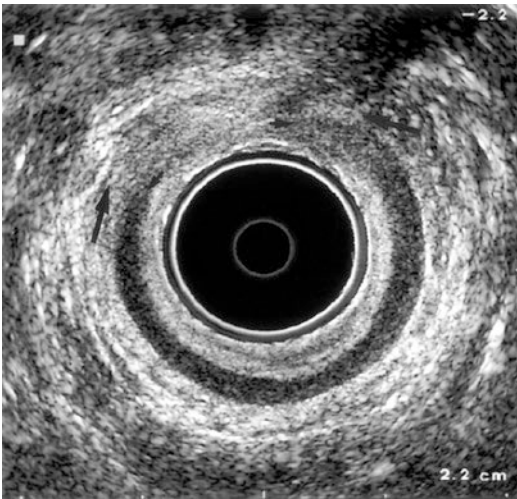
Endoanal ultrasound image of an anterior EAS damage due to obstetrical injury. (Reused with permission © American Gastroenterological Association)
